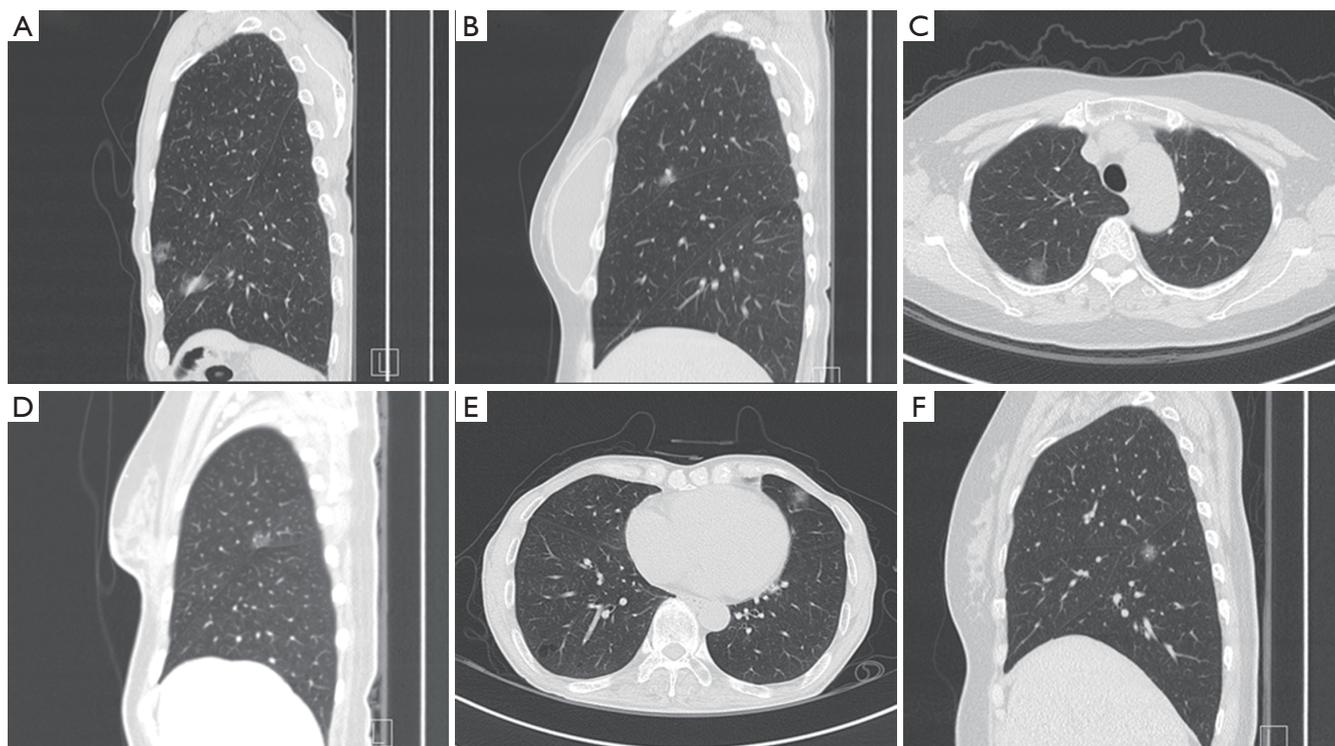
Pure ground-glass opacity, with or without pleural retraction, on chest computed tomography. (A) Adenocarcinoma in situ (AIS) without pleural retraction; (B) AIS with pleural retraction; (C) minimally invasive adenocarcinoma (MIA) without pleural retraction; (D) MIA with pleural retraction; (E) invasive adenocarcinoma (IA) without pleural retraction; (F) IA with pleural retraction.
